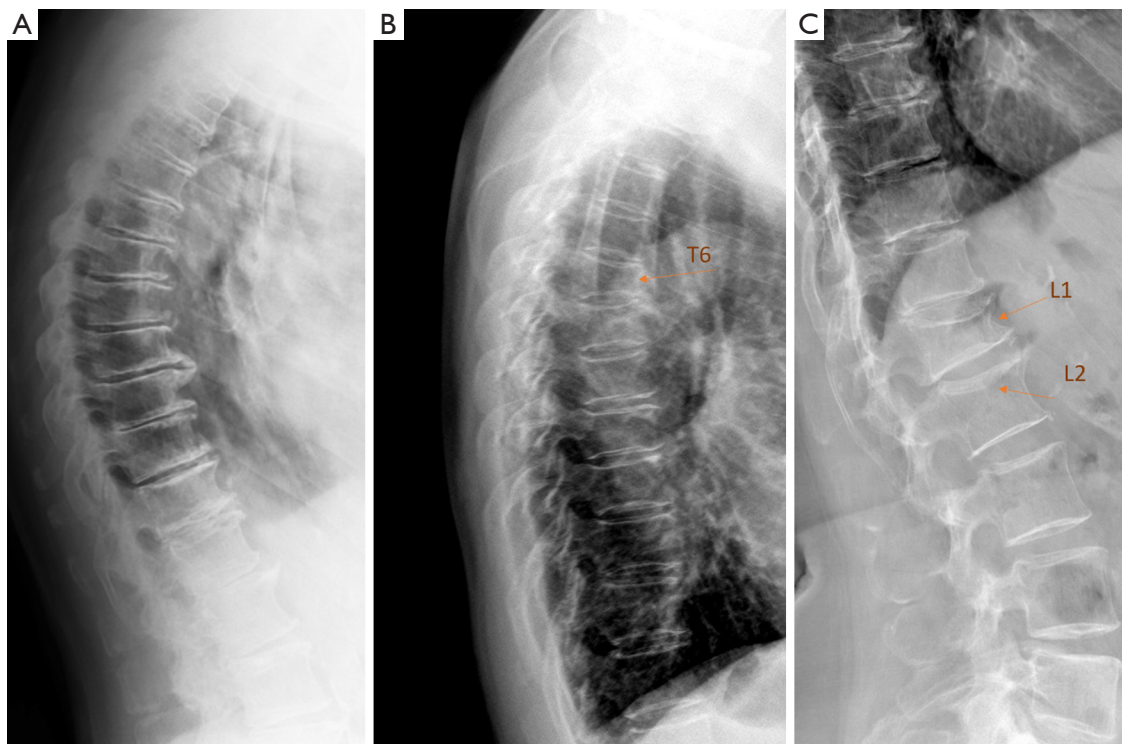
Degenerative changes and OVF. (A) Spine radiograph of an elderly women. Mid-thoracic region shows anterior wedging of multiple vertebrae with similar appearance, disc space narrowing and osteophytes are noted while without endplate depression. (B) Spine portion of a lateral chest radiograph of an elderly women, T6 vertebra shows distinct deformity consistent with OVF. (C) Spine radiograph of an elderly women. T6 vertebra shows distinct deformity consistent with OVF, while L2 shows upper endplate depression (i.e., endplate fracture). OVF, osteoporotic vertebral fracture.
